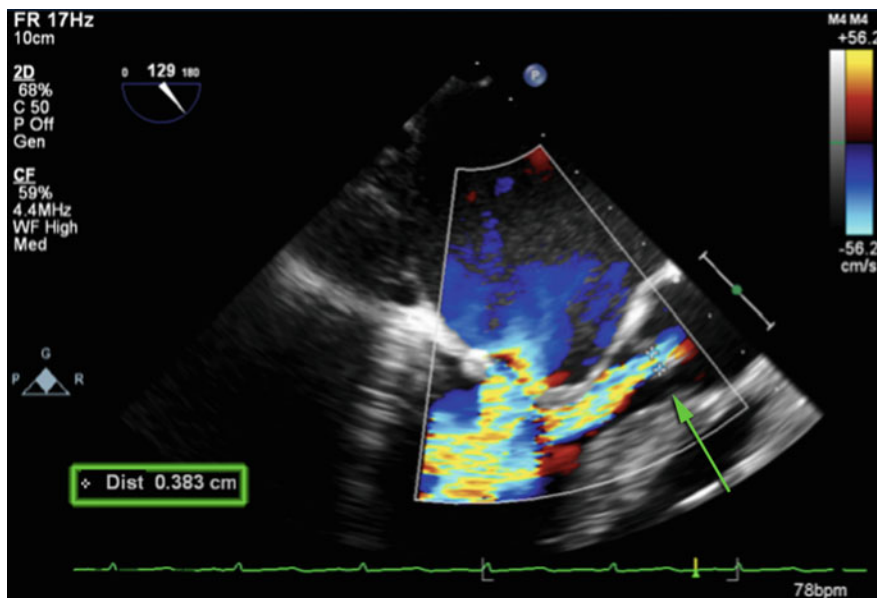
Vena Contracta: The ME AV LAX view with a color flow Doppler box over the mitral and aortic valves. Regurgitant flow can be seen entering the left ventricle. A caliper measurement (green arrow) is seen measuring the jet as it crosses the aortic valve showing a distance of 0.38 cm (moderate severity)
